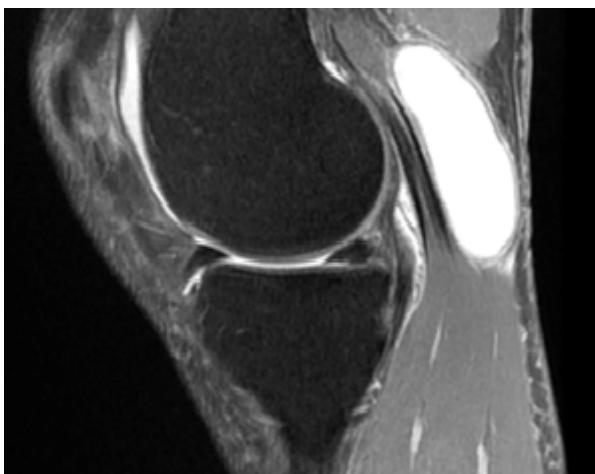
Sagittal proton density, fat saturated magnetic resonance image of the right knee demonstrating a 3.0 mm and 4.0 mm popliteal cystic process probably leaking fluid in the calf adjacent to the medial gastrocnemius and along the pes anserine tendon regions.
